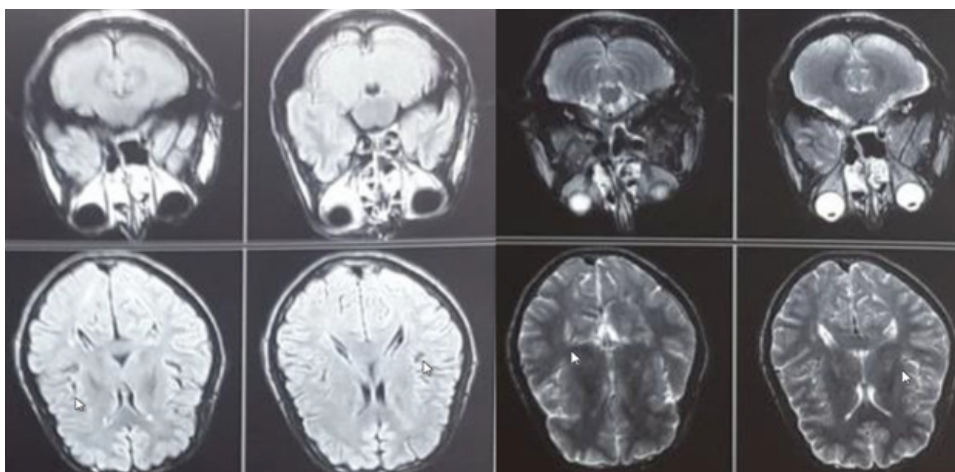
Foci of signals in centrum semiovale, both internal capsules and lentiform nucleus (MRI)
